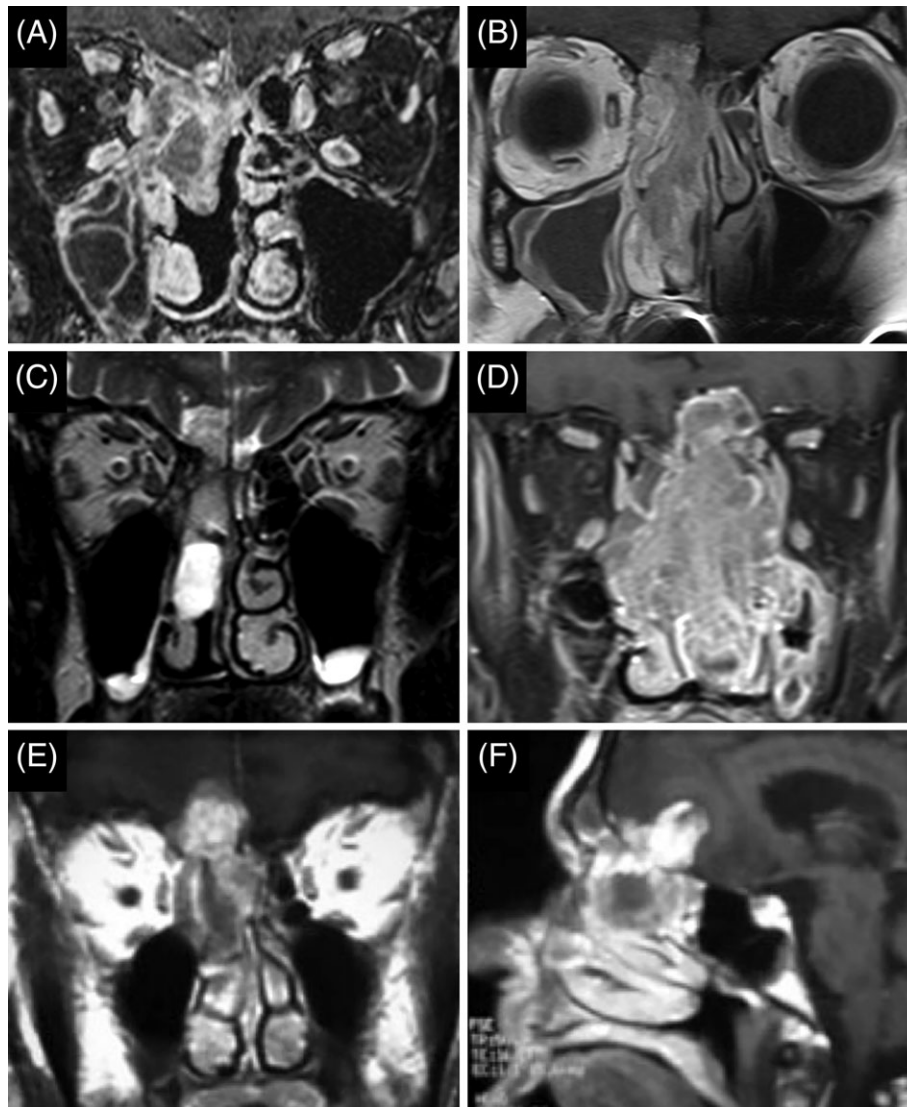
Preoperative MRI of patients #1, #4, #6, #9, and #10. A, T1-weighted, contrast-enhanced coronal section with fat saturation of patient #10. B, T1-weighted, contrast-enhanced coronal section of patient #9. C, T2-weighted, coronal section of patient #6. D, T1-weighted, contrast-enhanced coronal section with fat saturation of patient #4. (E,F) T1-weighted coronal and sagittal sections of patient #1
